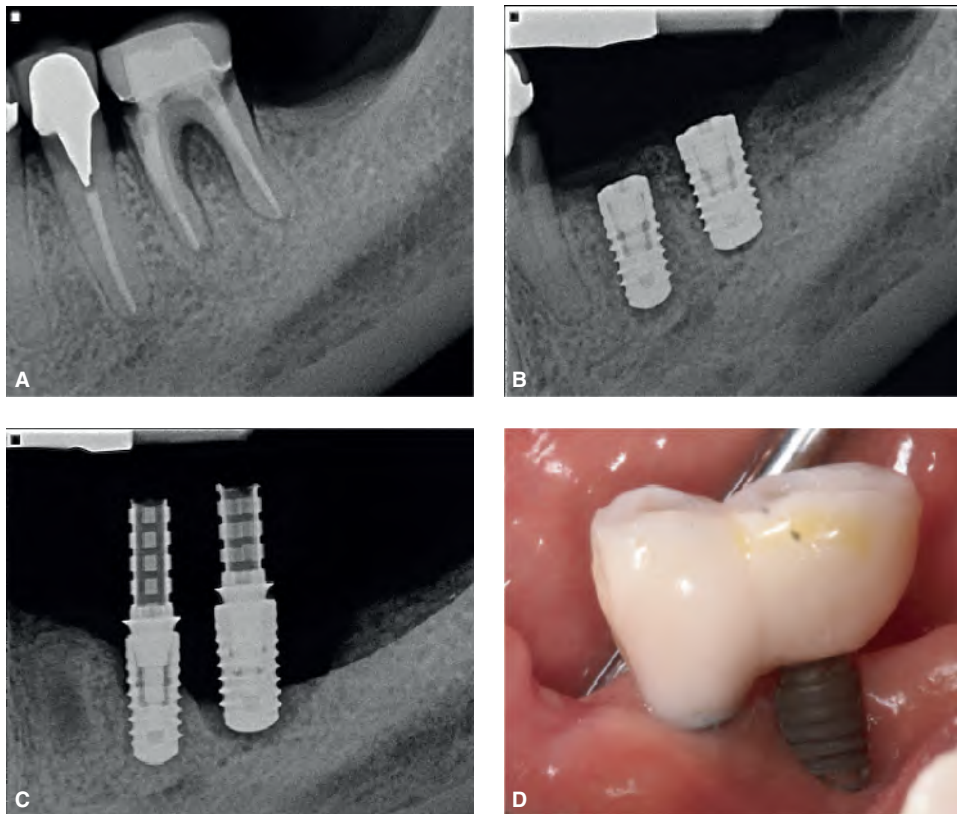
Implant placement may successfully address a problem if planned and executed appropriately. A. Periapical radiograph of the mandibular left second premolar and molar with questionable prognosis. B. The teeth were extracted and replaced with two implants. C & D. Eighteen months later, the implants are failing.
